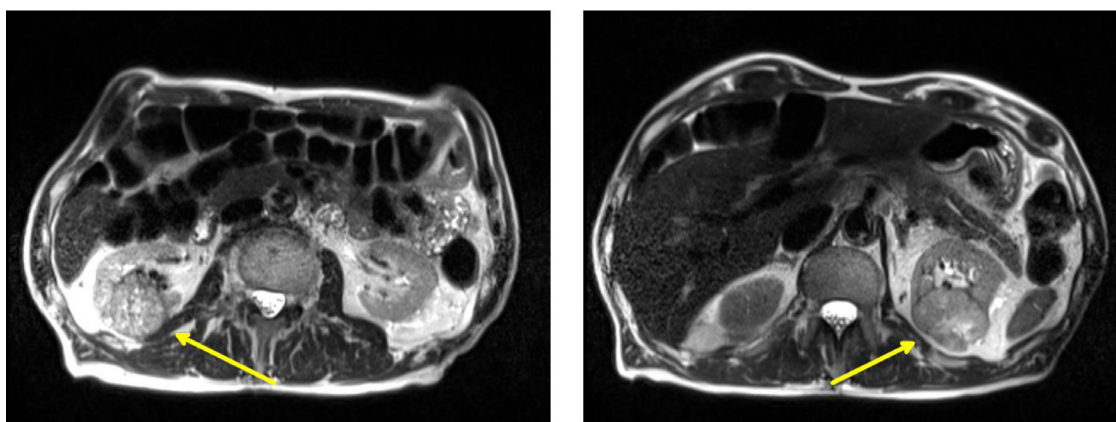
Magnetic resonance images with circumscribed 55 × 35 × 52-mm mass in the mid to lower pole of right kidney (left) and 53 × 40 × 44-mm mass in the upper pole of left kidney (right).
